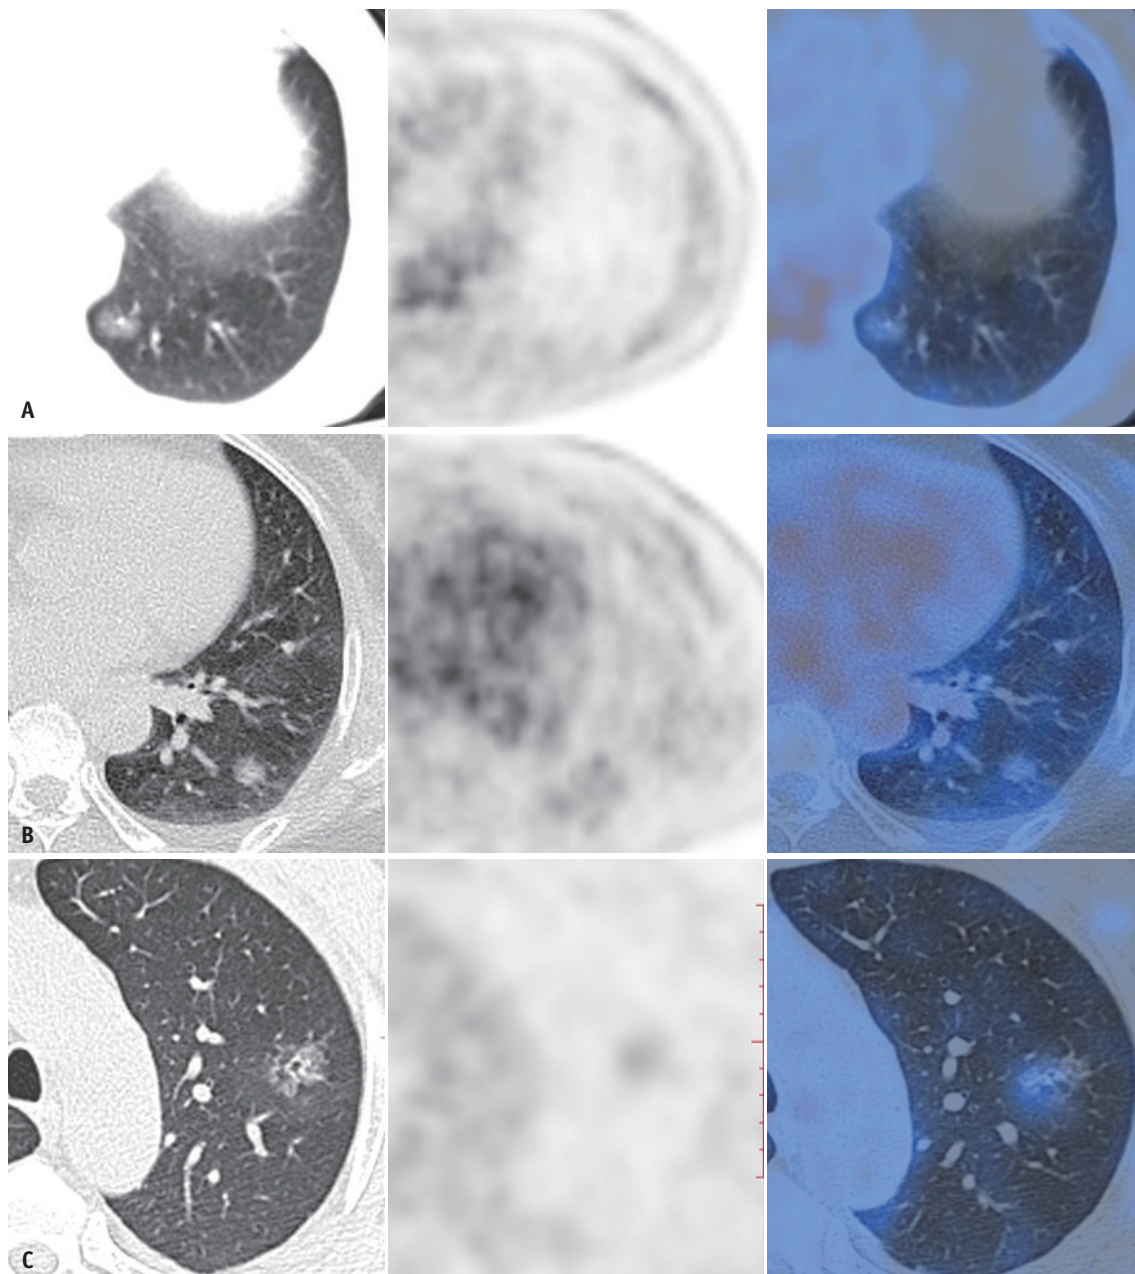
CT, PET, and PET/CT of AIS, MIA and invasive adenocarcinoma with low FDG uptake.
